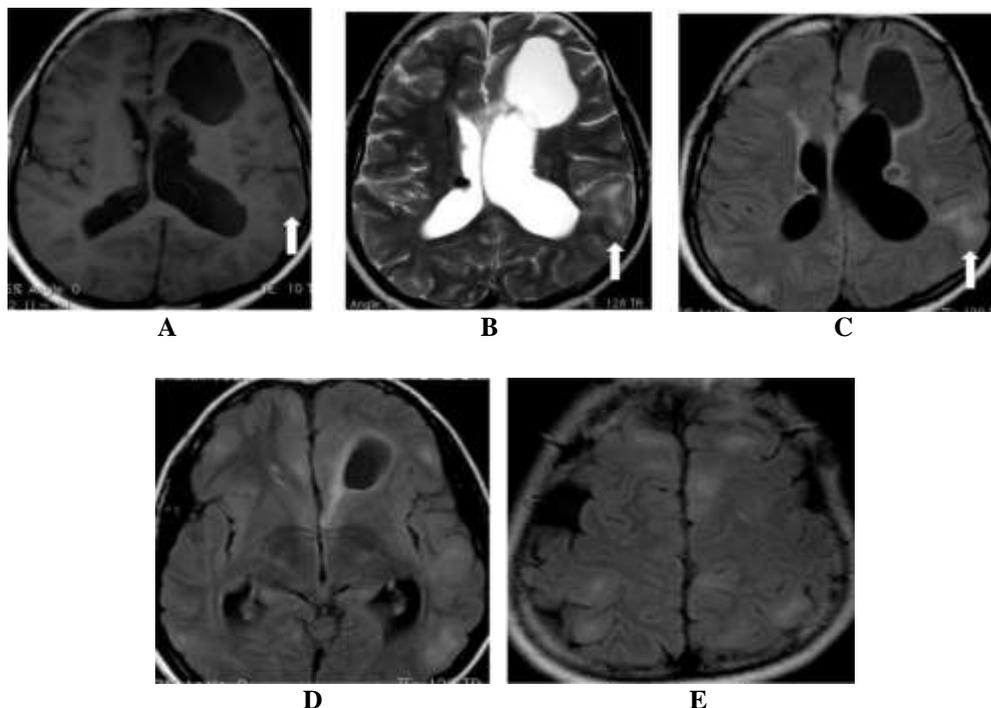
(A-E) In a known case of Tuberosclerosis with past history of surgical excision of SEGA and shunt tube in situ. Notice the expanded gyrus in the left parietal lobe appearing hypointense on T1 weighted (A) and hyperintense on T2 weighted and FLAIR (B & C) images. Also note the multiple cortical tubers involving the cerebrum, appearing hyperintense on FLAIR images (D & E).
